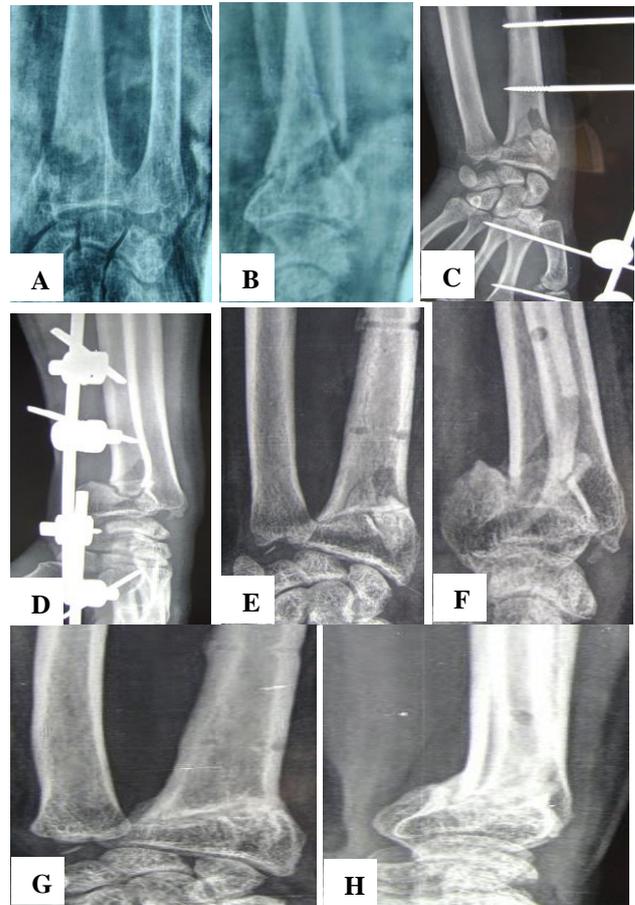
X-ray photographs of case 2.
